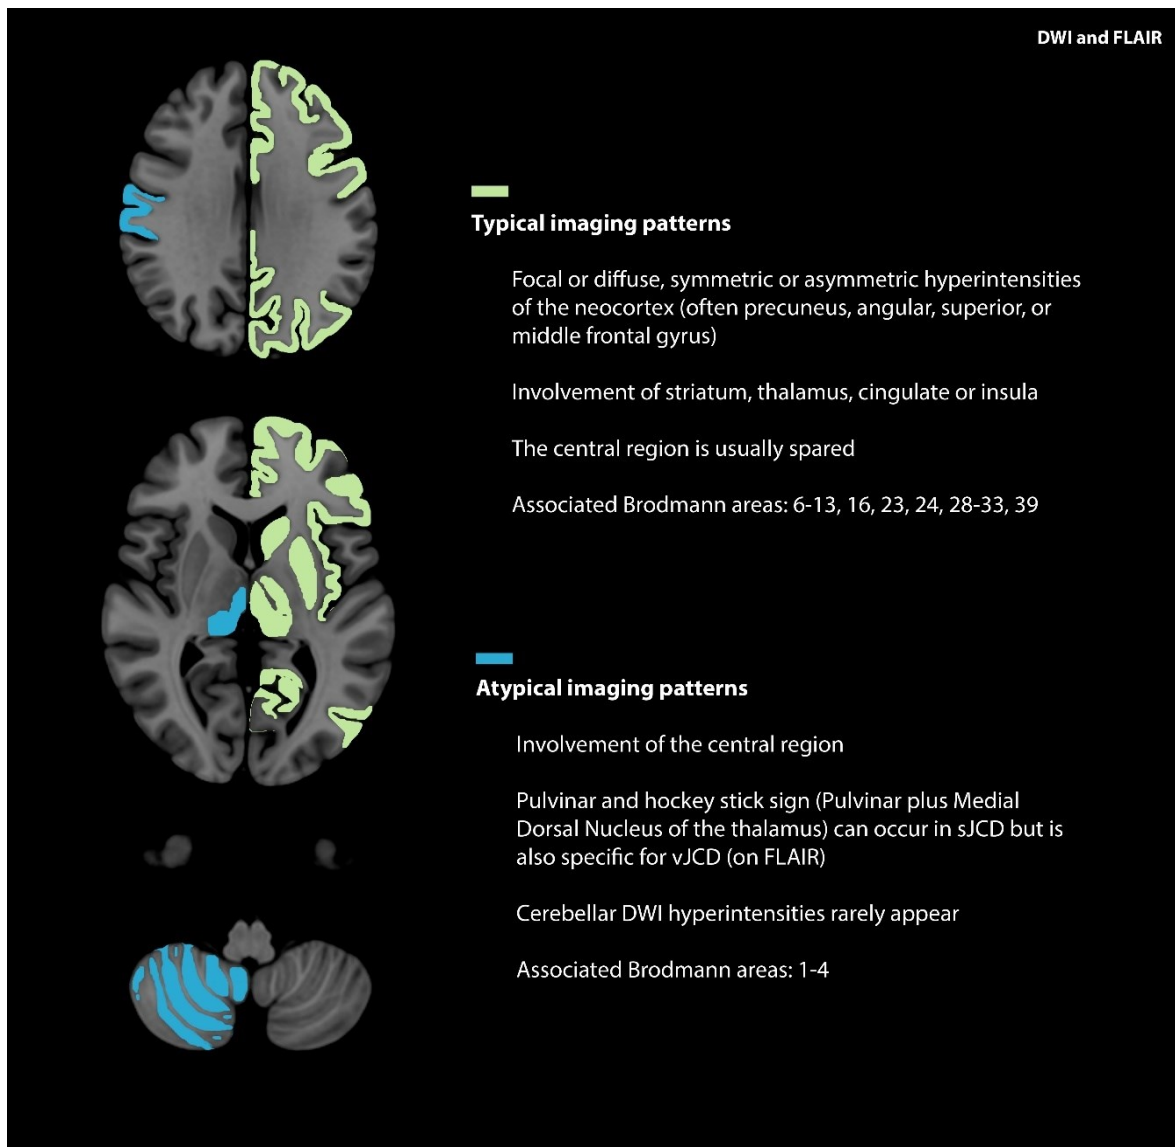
(2:p.7,46) Imaging patterns in sJCD. Typical (right side) and atypical (left side) patterns are seen in patients with sJCD on MRI. DWI images are more sensitive than FLAIR sequences.
